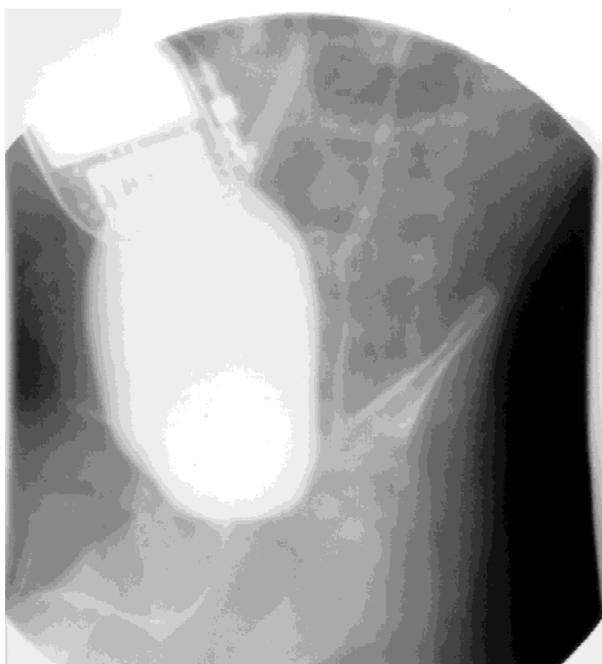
An anteroposterior chest radiograph shortly after pacemaker implant demonstrates the size of the pacemaker and its subxyphoid location.
